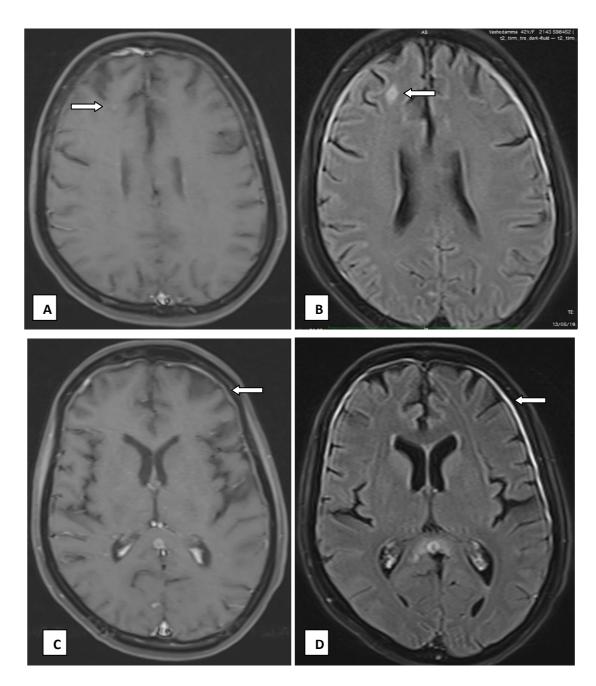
(A) T1 FS PC sequence shows a subcentimetric lesion with faint ring enhancement in right frontal lobe & same lesion on (B) T2 FLAIR PC sequence shows mild ring enhancement. (C) T1 FS PC sequence shows mild meningeal enhancement along the bilateral frontal convexities whereas on (D) T2 FLAIR PC sequence avid enhancement of meninges is seen. Therefore, in this case, T2 FLAIR PC sequence proved to be superior to T1 FS PC sequence.
